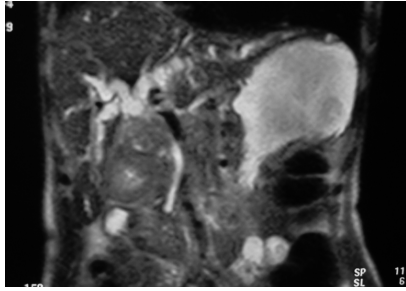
T2 weighted coronal MR image showing mass in gall bladder and CBD with IHBRD
